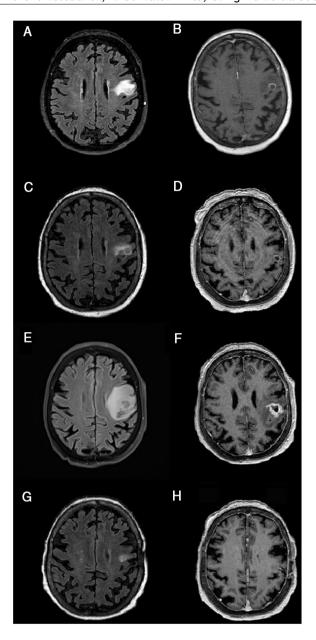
Brain MRI scan showing lesion progression. A-B) At admission. C-D) After 21 days of treatment. E-F) After 2 months of treatment. G-H) After 3 months of treatment. FLAIR (A, C, E, G) and gadolinium-enhanced T1-weighted sequences (B, D, F, H), axial plane. Images show the progression of a corticosubcortical lesion located in the left precentral gyrus/frontal operculum; the lesion is rounded and well defined, and appears iso- and hyperintense on FLAIR sequences (A, C, E, G) and hypointense on T1-weighted sequences (B, D, F, H), surrounded by vasogenic oedema and with contrast ring enhancement (B, D, F, H). Lesion size at admission was 15×12 mm (anteroposterior \times lateromedial) (A). After a slight decrease in lesion size (12×7.5 mm) and significant improvements in the perilesional oedema (C), with contrast ring enhancement remaining nearly unchanged (D), remarkable increases were observed in lesion size (16×16 mm) and vasogenic oedema (E), as compared to the previous study (D). The lesion also changed in terms of morphology (more heterogeneous) (D), and displayed more extensive and irregular contrast uptake (F). Significant improvements were observed 3 months after onset of treatment with ibrutinib, with a decrease in lesion size and improvement in oedema (G); contrast uptake was barely perceptible (H). Changes were observed after craniotomy (biopsy) (G, H).
